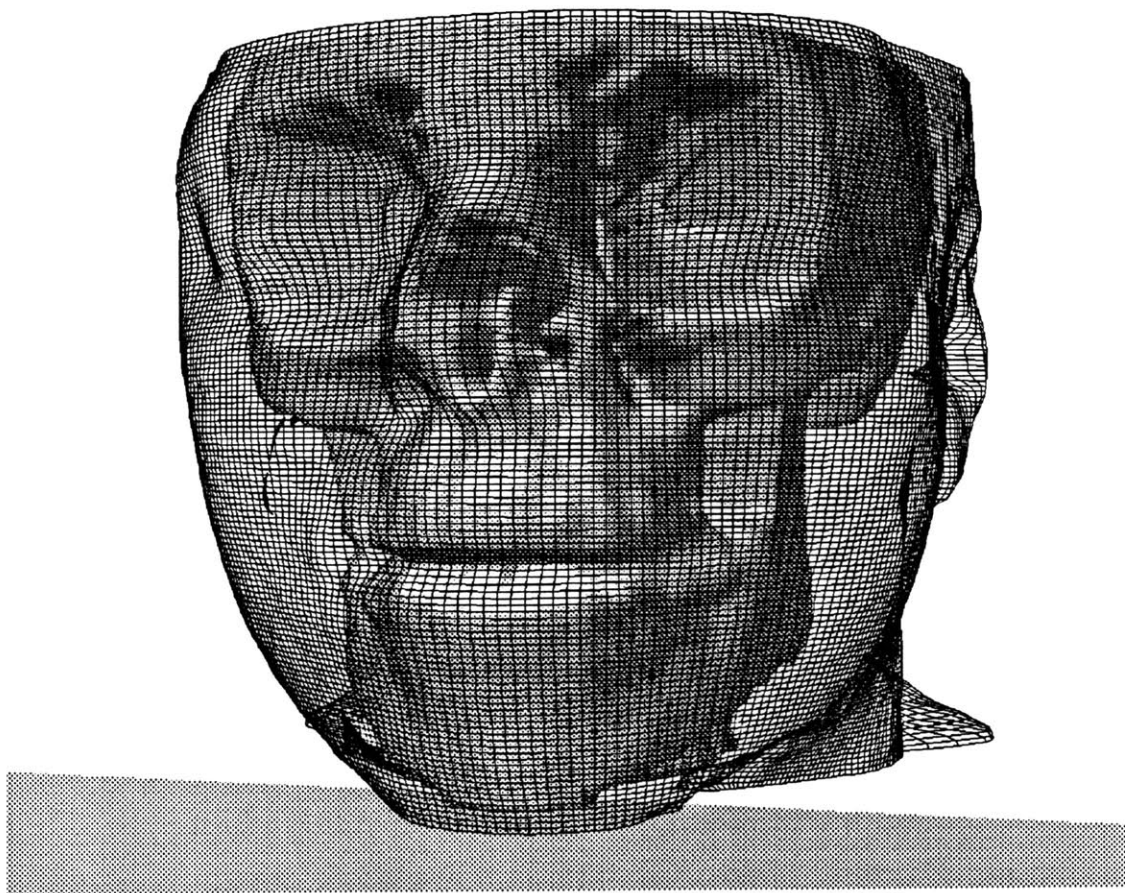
CT scan reconstruction with skin drawn as lines.
